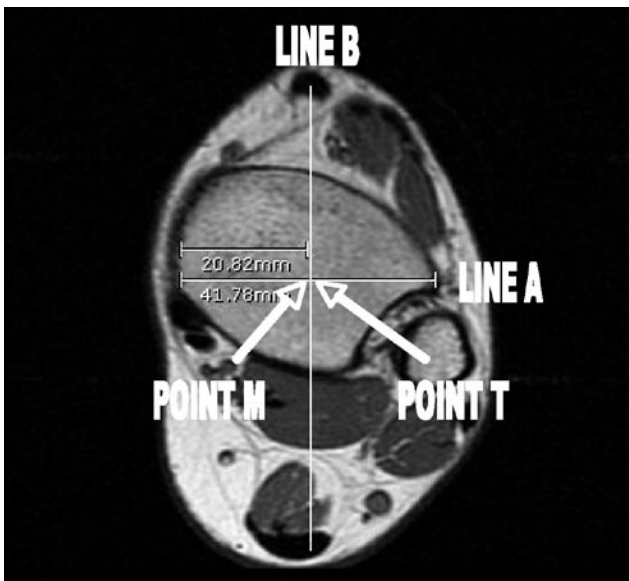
Magnetic resonance imaging of distal tibia just above plafond. Line A is drawn through the widest aspect of the distal tibia in the coronal plane. Line B is a perpendicular line drawn in the sagittal plane from the center of the tibialis anterior tendon. Point M is the midpoint of line A. Point T is the point of intersection between lines A and B, representing the tibialis anterior tendon. The distance between points M and T is measured. There is almost no difference between points M and T.
